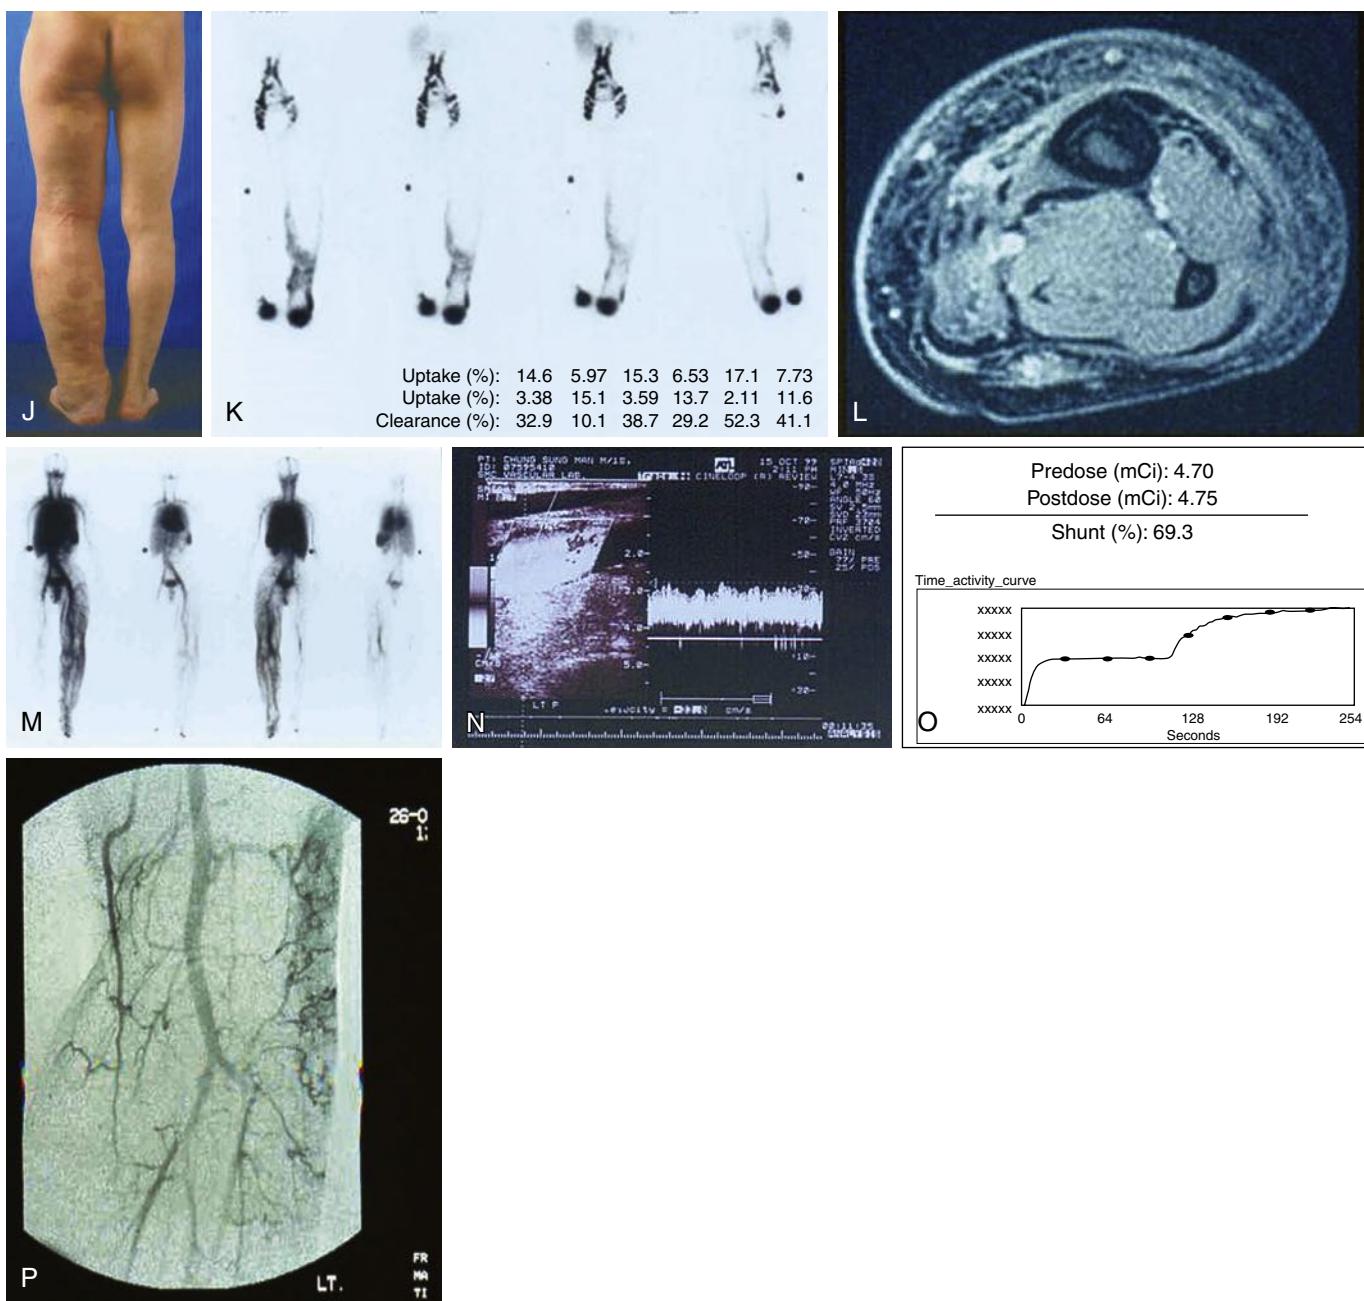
Cont'd. (J), similar to the findings in KTS (see A). Radionuclide lymphoscintigraphy (K) and MRI (L) reveal primary lymphedema caused by a truncular LM. WBBPS (M) shows diffuse, abnormal blood pooling throughout the limb due to an extratruncular VM. Duplex ultrasonography (N) depicts a hyperdynamic arterial condition secondary to an AVM. TLPS (O) reveals the precise shunting percentage (69.3%) through the hidden AVM shunts. Arteriography (P) demonstrates multiple superficially located microshunting AVMs scattered throughout the lower extremity. The clinical diagnosis of PWS was confirmed (with LM, VM, AVM, and capillary malformation components).
